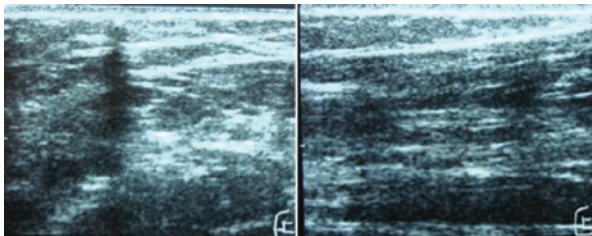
Ultrasound of the arm cross section. Drop-like image of the implant and longitudinal section, linear image of the implant with its acoustic shadow.
